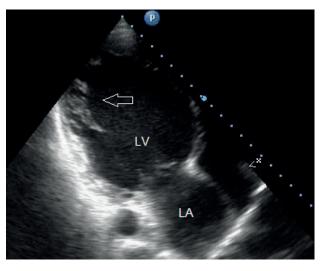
Patient 32 y.o. Echocardiography, modified 4-chamber view. Arrow – non-compacted layer of lateral LV wall.
